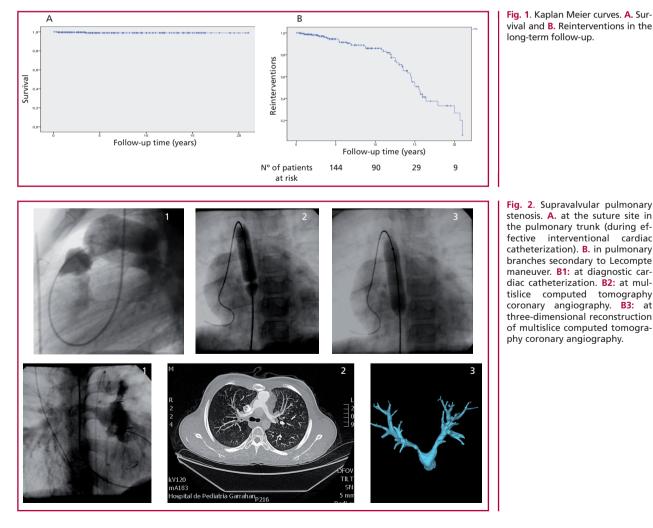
Supravalvular pulmonary stenosis. A. at the suture site in the pulmonary trunk (during effective interventional cardiac catheterization). B. in pulmonary branches secondary to Lecompte maneuver. B1: at diagnostic cardiac catheterization. B2: at multislice computed tomography coronary angiography. B3: at three-dimensional reconstruction of multislice computed tomography coronary angiography.
